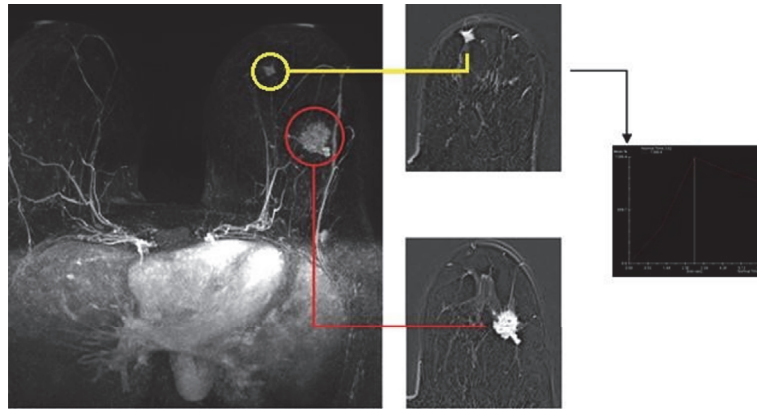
Index lesion (red circle; left SEQ, 28 mm), already documented with mammography and ultrasound. MRI leads to the detection of multicentric disease, confirmed to US second look and biopsy (yellow circle: left IIQ, 9 mm) (SEQ: Superior External Quadrant; IIQ: Inferior Internal Quadrant).
